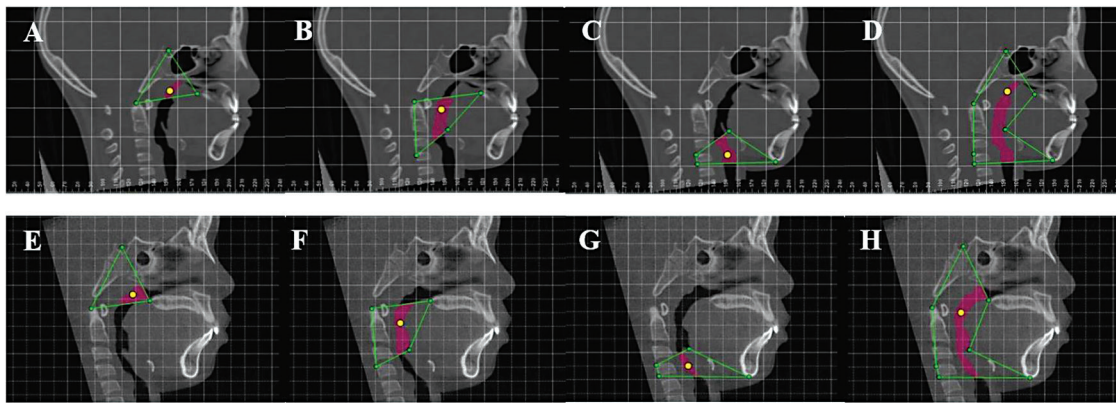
Assessment in sagittal view from CBCT in Dolphin software: (A) - (D) images were example images from UCLP subject, and (E) - (F) images were example images from non-cleft subject. (A) and (E); The image of nasopharyngeal airway (Sella-PNS-tip of odontoid process), (B) and (F); The images of oropharyngeal airway (tip of odontoid process - PNS - base of epiglottis - posterior-superior corner of C4), (C) and (G); The images of hypopharyngeal airway (posterior-superior corner of C4 - base of epiglottis - inferior border of symphysis - posterior-inferior corner of C4), and (D) and (H); The images of total upper pharyngeal airway spaces (all landmarks were used to construct the areas).
